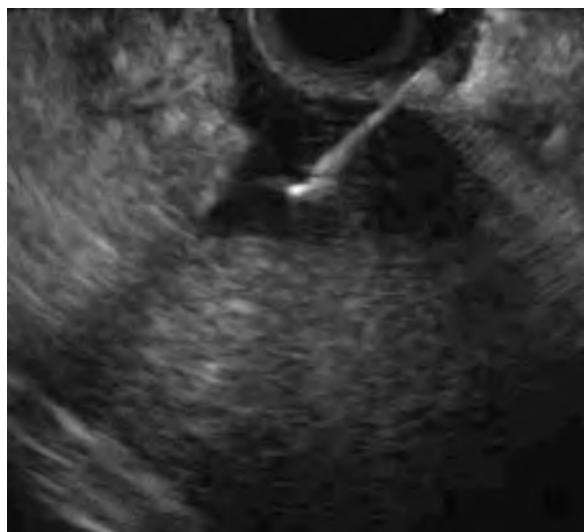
Endoscopic ultrasound–guided fine-needle aspiration of a lymph node.
